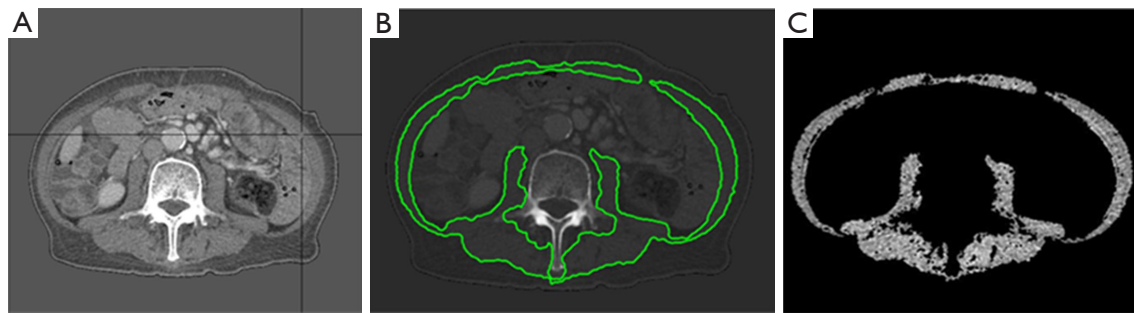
SMI measurements. (A) A transverse CT scan section at the level of the third lumbar vertebra. (B) The green line area covered by the skeletal muscle (including the psoas, paraspinal, external oblique, internal oblique, transverse, and rectus abdominis muscles). (C) The skeletal muscle surface was calculated from pixels in the density range of -29 to $+150$ HU. Reprinted with permission from Sunpaweravong S, Vongcharoenpol T, Leelakiatpaiboon S, *et al.* Sarcopenia following concurrent chemoradiotherapy for locally advanced esophageal squamous cell carcinoma (abstract only). *Clinical Nutrition ESPEN* 2023;58:621. CT, computed tomography; SMI, skeletal muscle index.
